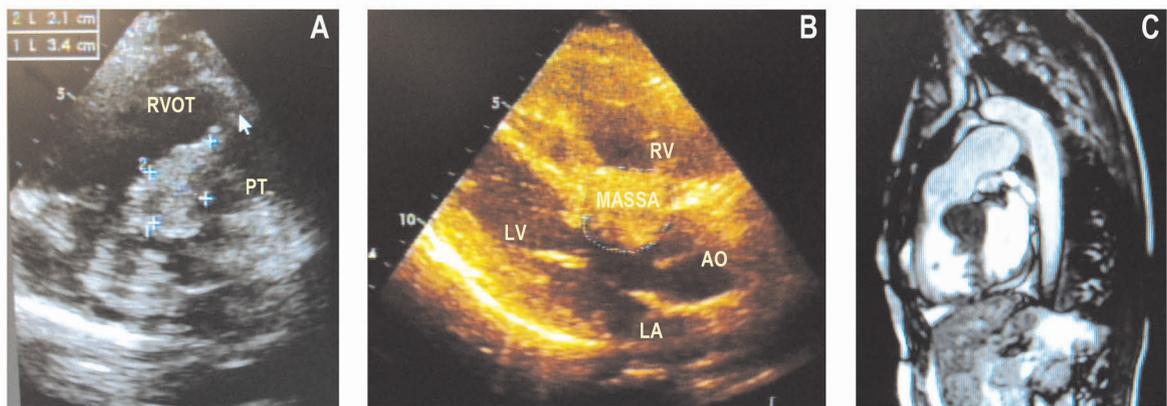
Echocardiogram shows an obstructive mass in the right ventricular outflow tract in parasternal short axis at A, restricted to the interventricular septum in longitudinal section in B, and clear obstruction of right ventricular outflow tract on magnetic resonance imaging in C.
